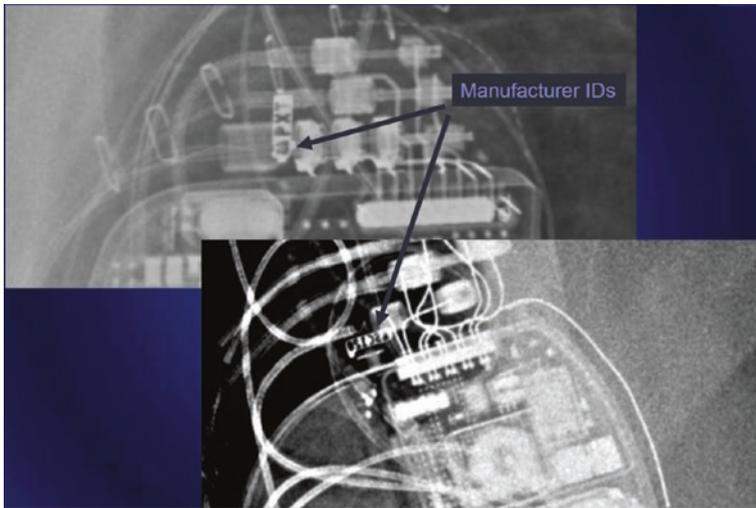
Magnified view of a chest x-ray showing manufacturer ID of a cardiac implantable electronic device
